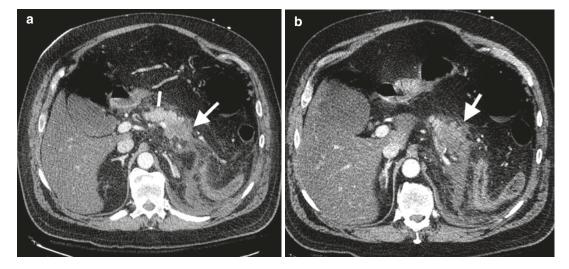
Acute necrotic pancreatitis on axial arterial phase CT through pancreas, (a, b) note normal pancreatic enhancement proximal body (*line*) and diminished
